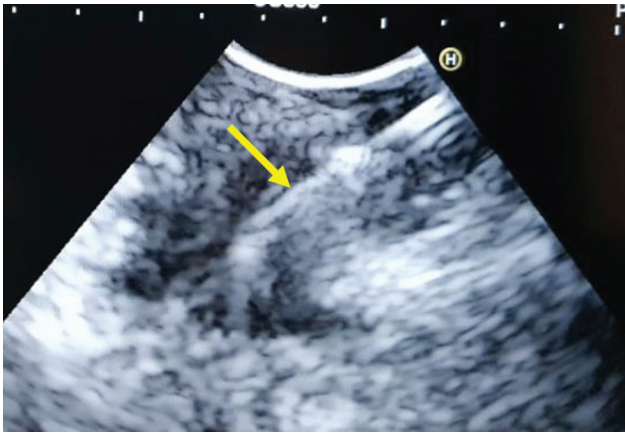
Real-time endobronchial ultrasound (EBUS) guided lymph node sampling showing needle tip within the lymph node (arrow).
